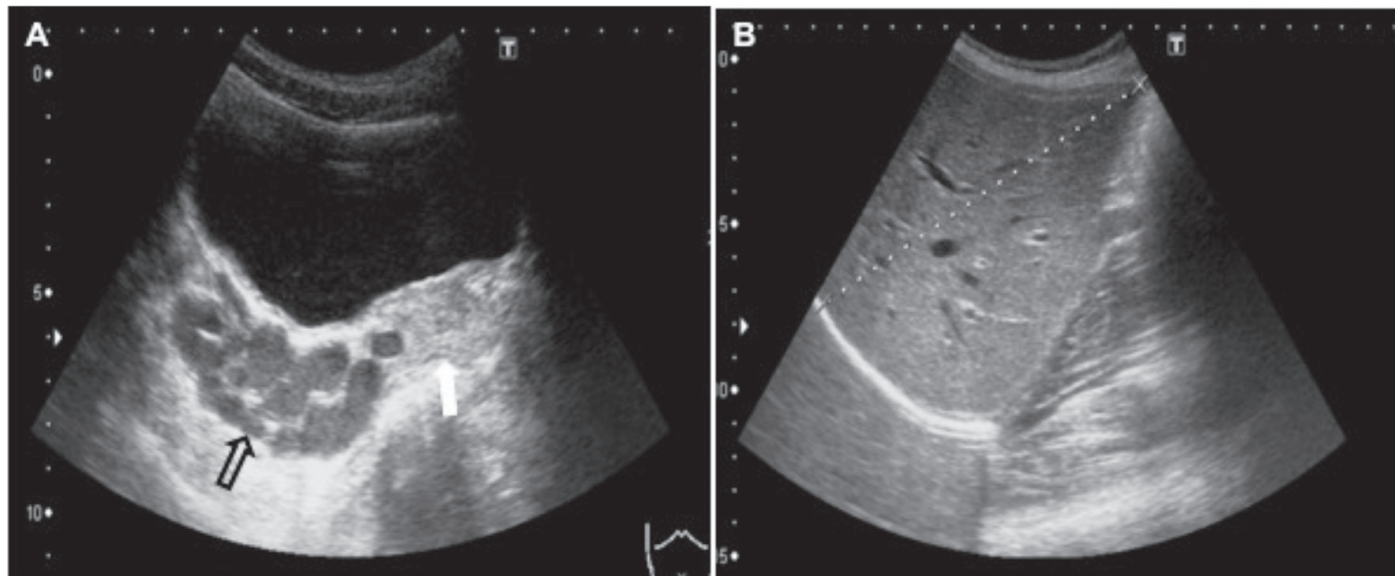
A) Pelvic ultrasound shows a multiloculated cystic structure (open arrow) in the right side of the pelvis inferolateral to the urinary bladder and adjacent to the prostate (white arrow). The mass has low level internal echoes, resulting from haemorrhage or increased proteinaceous content; B) absent right kidney in the renal fossa
